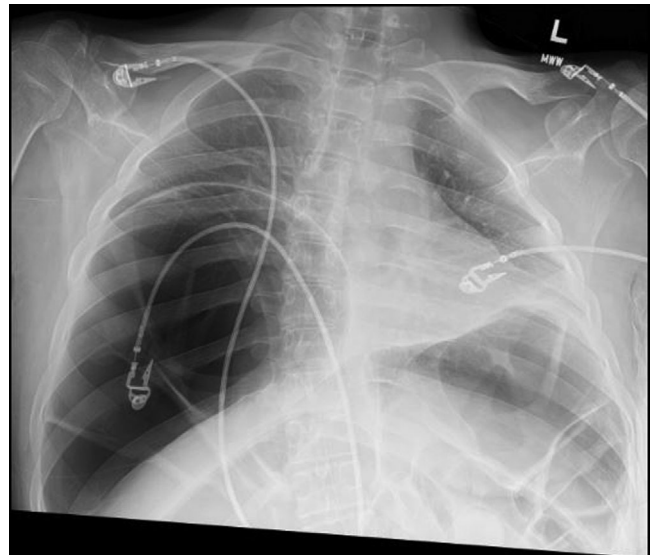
Chest radiograph demonstrating low lung volumes and elevated right hemidiaphragm secondary to massive colonic dilation
